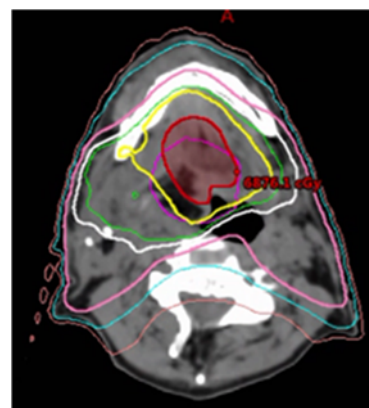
IMRT treatment plan CT slice for Stage III, T3N0 squamous cell carcinoma of base of tongue. Yellow line is 7000 cGy, the prescription dose for the primary tumor (red). The radiation oncologist felt tumor arose on right, therefore the right nodal volume was at greater risk, so has elected to relatively spare the left parotid and adjacent lymph nodes. Image courtesy of the University of Massachusetts Medical School, Department of Radiation Oncology.
